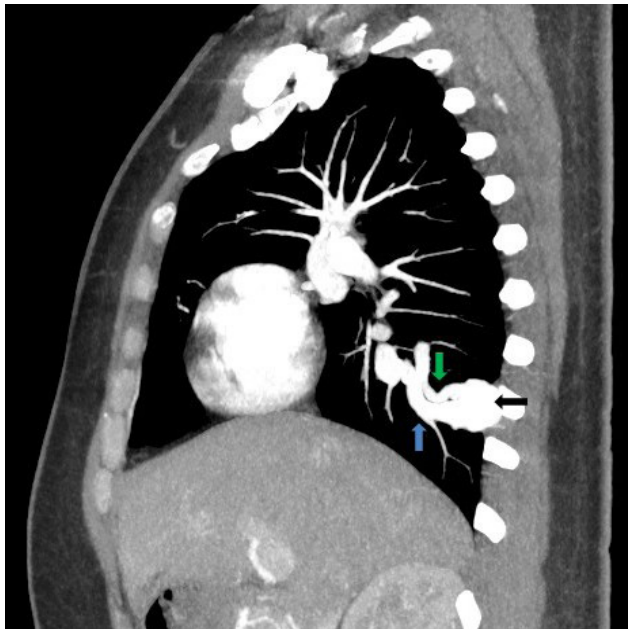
Sagittal CT scan with contrast medium showing an aneurysmal sac fed by an artery and drained by a dilated drainage vein.
